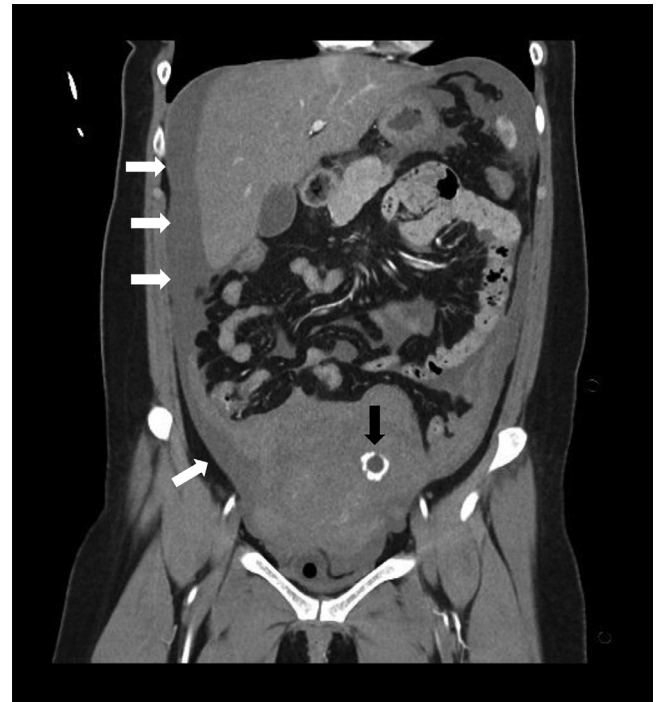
The contrast-enhanced multidetector CT (MDCT) pelvic images of the case at the early stage of the vaginal artery - owl's-eye appearance. The enhanced contrast was around the fetal sac (black arrow) at an early stage. It was referred to as "owl's eye" appearance in the low density peritoneal space.
